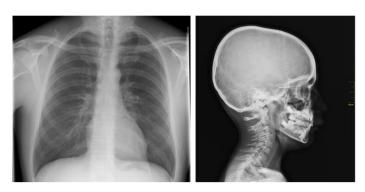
(left) X-ray chest projection with overlaying information; (b) vertebral column and head x-ray projection.
